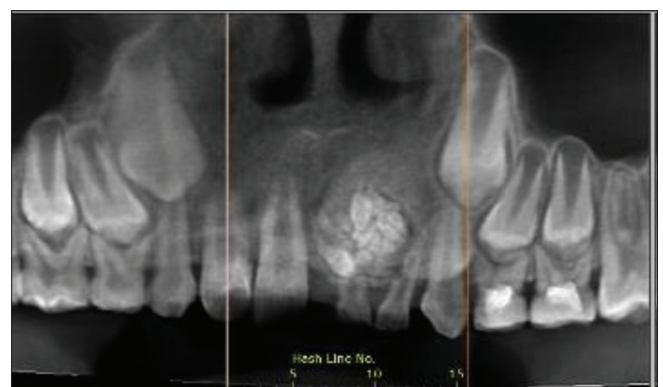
Panoramic reconstructed cone-beam computed radiographic image show odontoma; a pericoronal mixed-opaque lesion in anterior of maxilla
